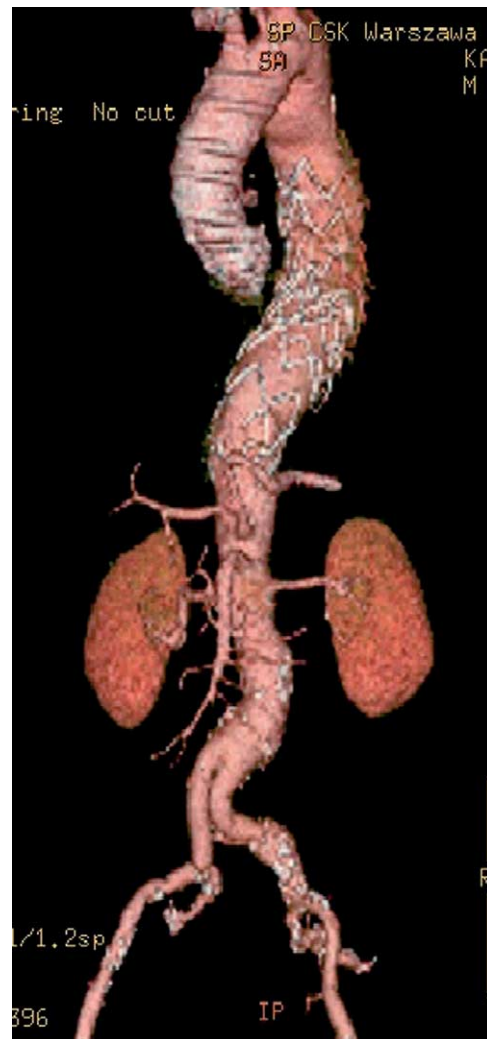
Pre-discharge CT-scan 3D reconstruction of the aorta.
